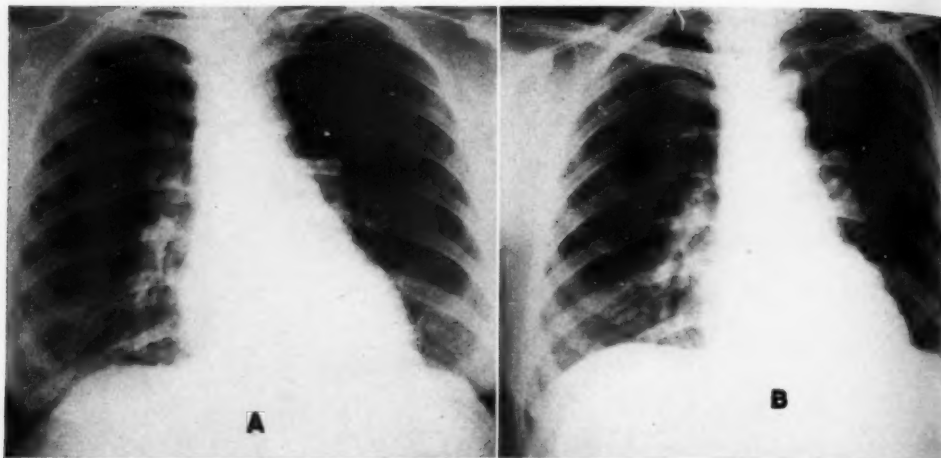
Hilar node enlargement. A. Roentgenogram with normal pressure. B. Roentgenogram with high pressure.
